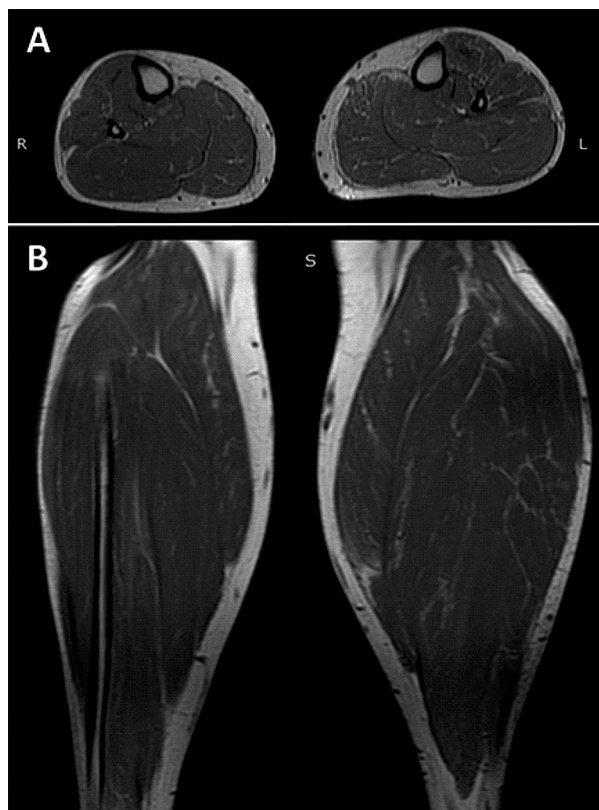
Magnetic resonance imaging (MRI) in transverse (A) and coronal (B) plane. Muscle hypertrophy of the left calf, particularly the medial and lateral head of the gastrocnemius muscle; the skin, subcutaneous tissue, and bones of similar size bilaterally, normal
